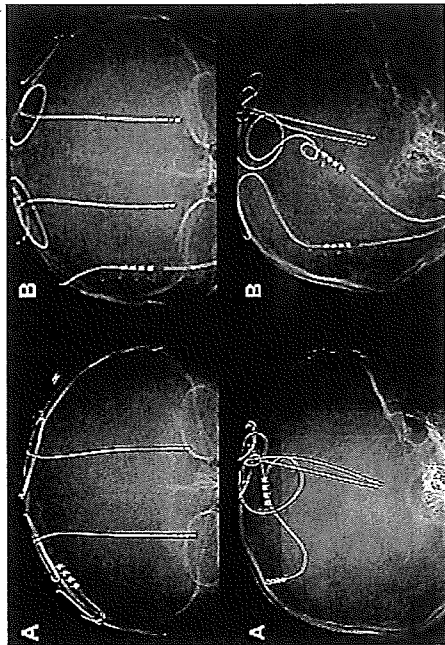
Dorsal lead migration shown by serial x-rays. A) A skull x-ray at one month post-implantation. B) A skull x-ray at eight months post-implantation. Left and right leads had deviated from baseline.
